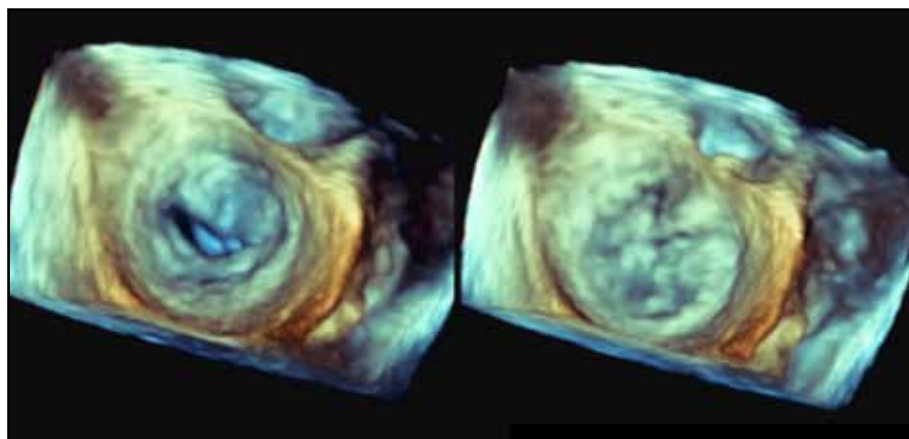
Three-dimensional trans-oesophageal echocardiogram of the mitral valve in a patient with mitral stenosis. Left: Restricted opening. Right: Closed
